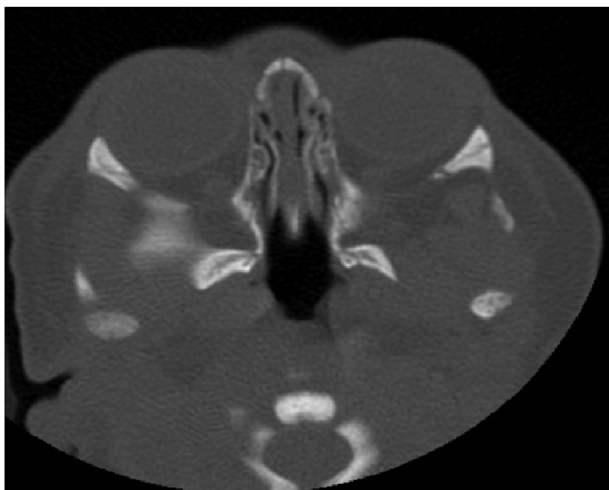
CT scan of patient 6 showing midnasal stenosis.
